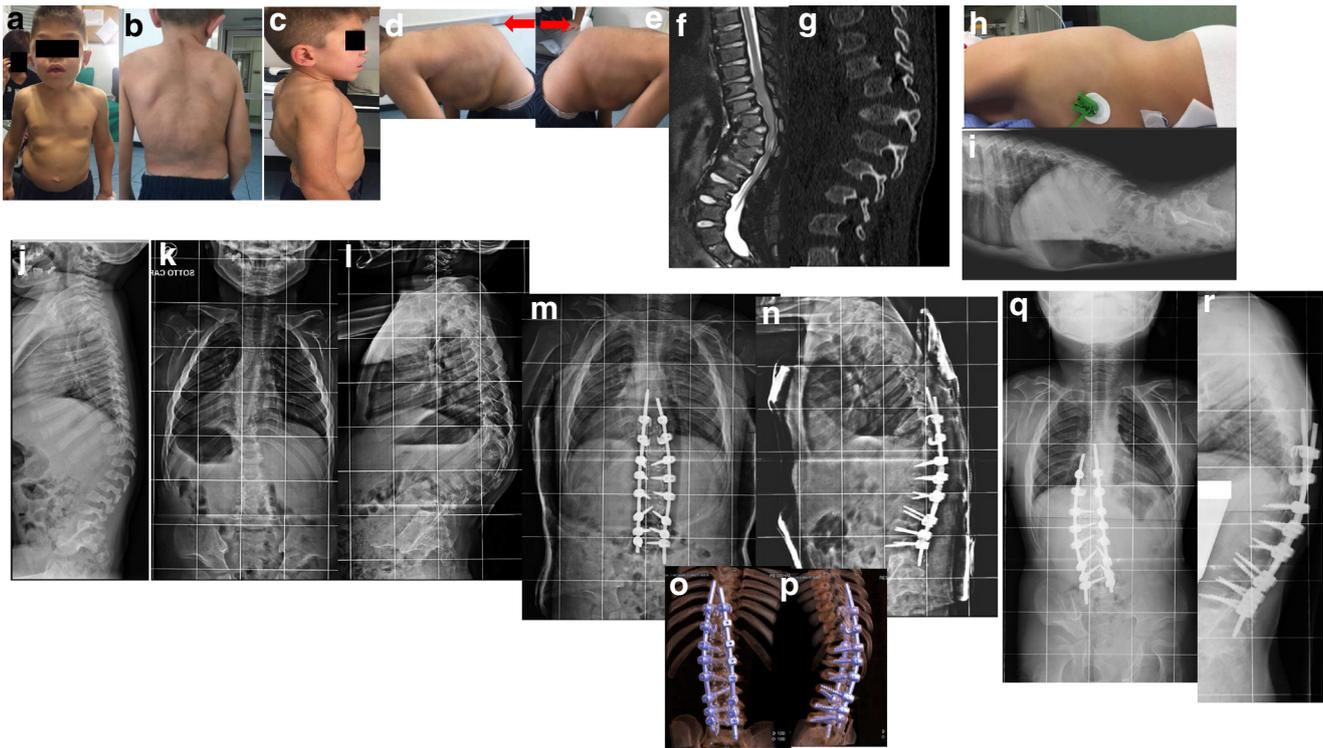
M.E. A 7-year-and-7-month-old boy affected by MPS I with worsening thoracic lumbar kyphosis, unsuccessfully treated by brace since 4 years of age; a, b, c, d, and e: clinical appearance with thoracic lumbar “gibbus”; f MRI of thoracic lumbar kyphosis showing vertebral canal narrowing with compression on nervous structures: patient had nervous symptoms complaining paresthesia in both legs and showing limbs somatosensory evoked potentials slowed down; g CT scan of thoracic lumbar kyphosis showing vertebral canal narrowing. h and i kyphosis was partially reducible in extension. j: M.E. at 4 years of age, lateral standing radiograph shows 30° Cobb T10-L4 kyphosis, treated by
